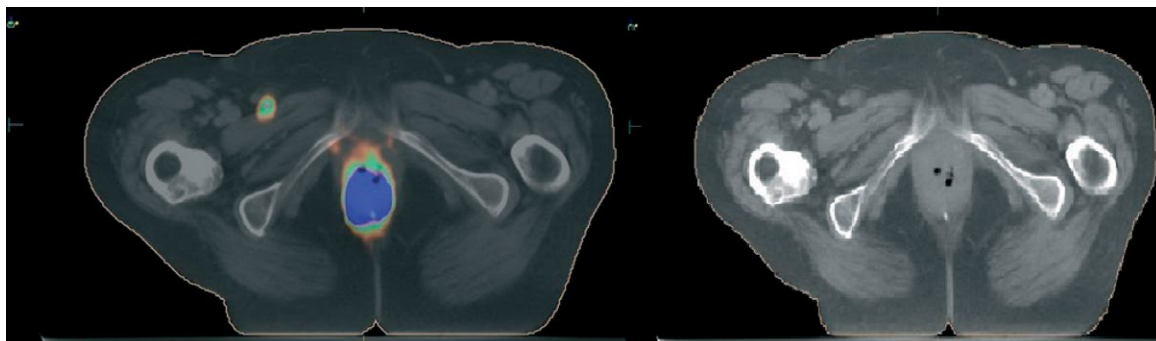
PET CT fusion and image registration vs CT data only
